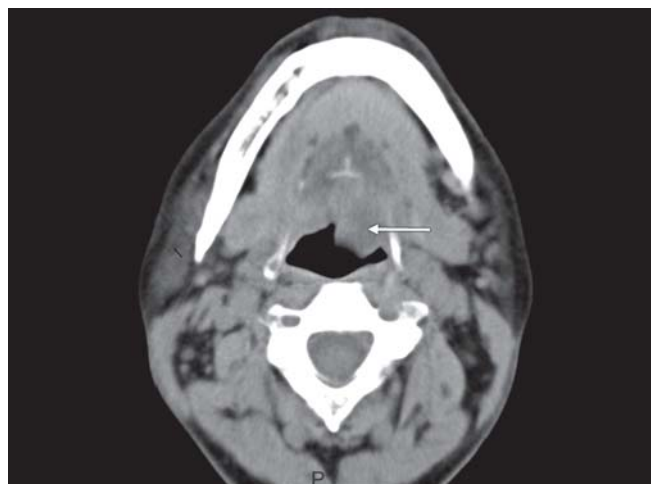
CT scan of head and neck showing well-defined cystic lesion in left vallecula (CT scan with nonionic contrast, lesion is nonenhancing, slice thickness 5 mm)
